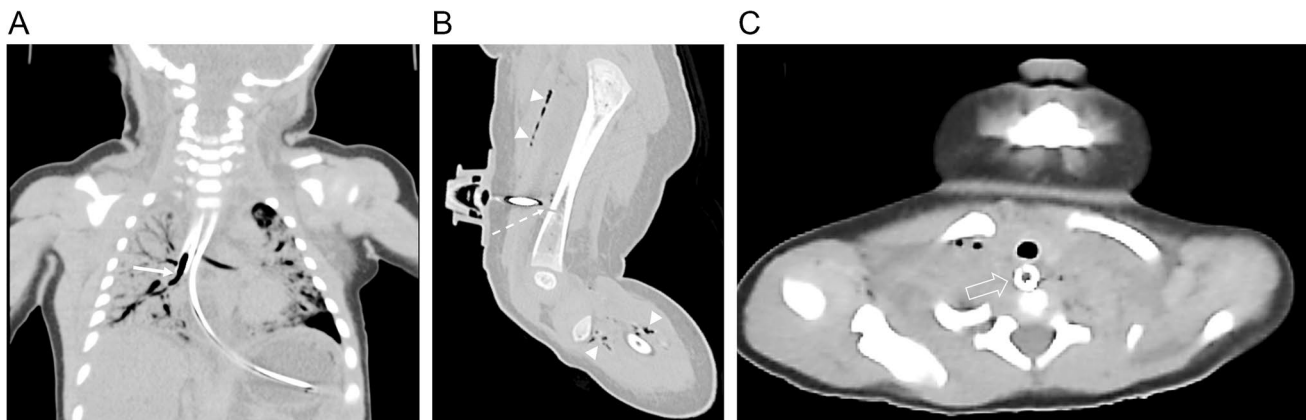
Postmortem computed tomography should include images with support devices in place both for helping to correlate with any local tissue changes found on autopsy that may result from device placement and for training and feedback. a, b A 2-month-old boy who was a victim of inflicted injury. a A coronal reformatted image of the chest shows the endotracheal tube tip to be in the right bronchus intermedius (*arrow*). b A sagittal reformatted image of the left femur shows an intraosseous needle with its tip in the anterior soft
